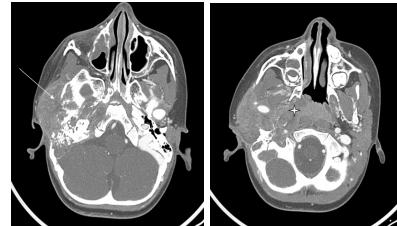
CT Scan of Temporal bones: Lobulated heterogeneous enhancing mass lesion in the right temporal region, extending into the nasopharynx.
